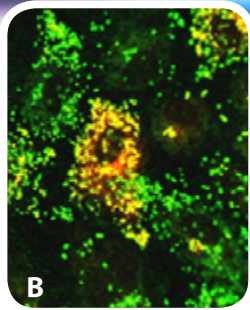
A 3D model of an ankle joint created using CT scanning. Image B: OPG selectin image. Image C: a pit in a dentine slice created by osteoclasts grown in vitro.
